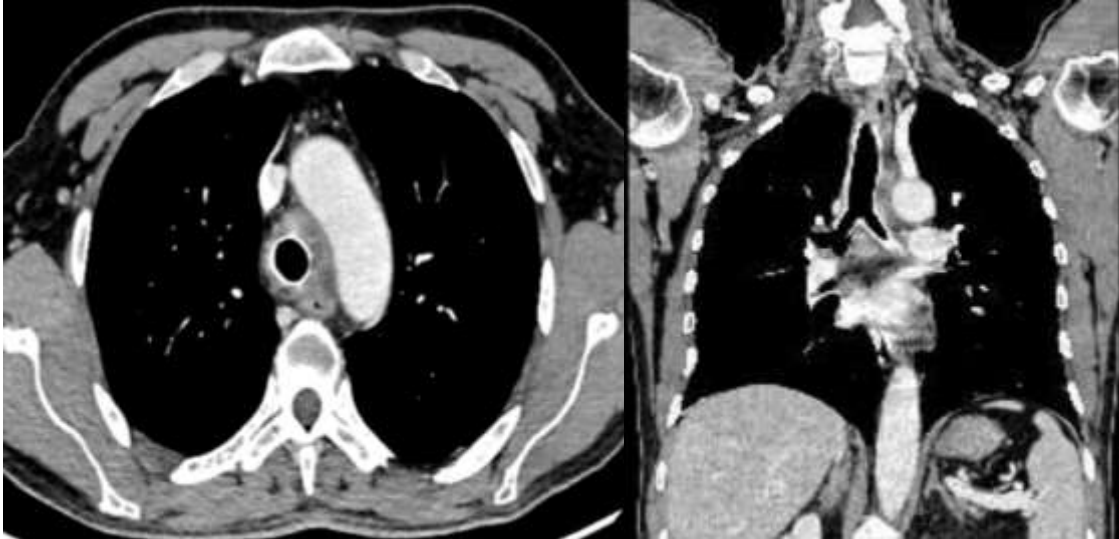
(A, B):- Chest CT in Mediastinal Window: Axial and Coronal Sections after the placement of the tracheal stent.
